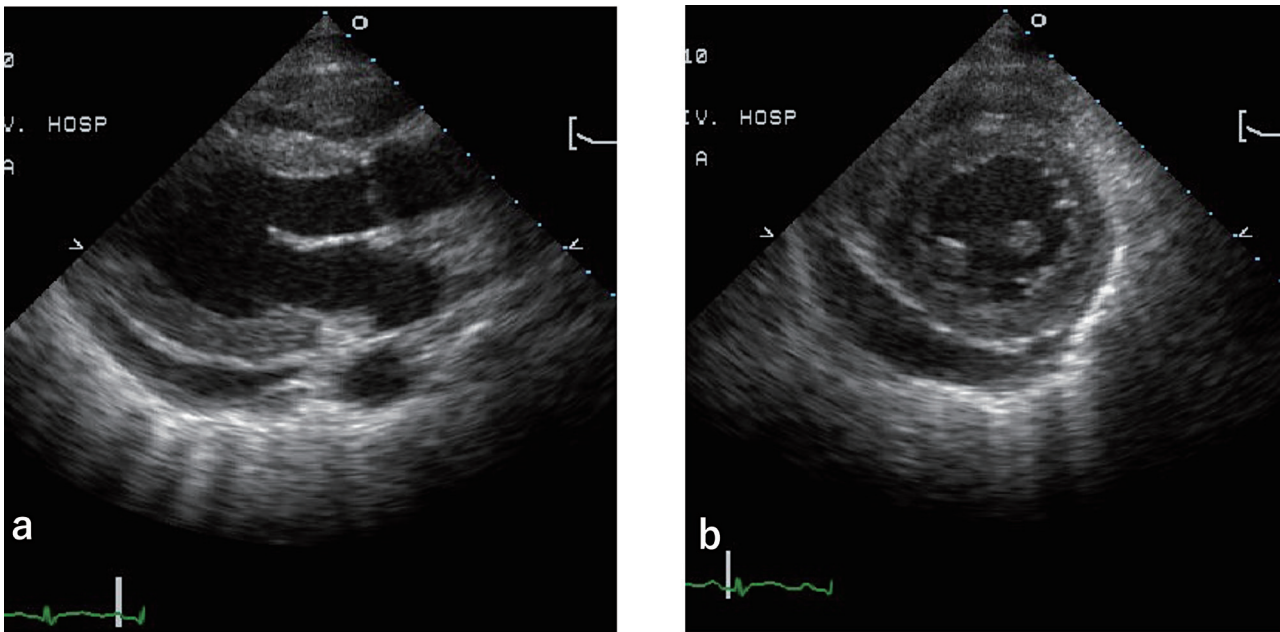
Routine echocardiography on admission. Parasternal (a) and short axis (b) Echocardiography showed hypokinesis and mild hypertrophy of the left ventricle wall, and moderate pericardial effusion.
